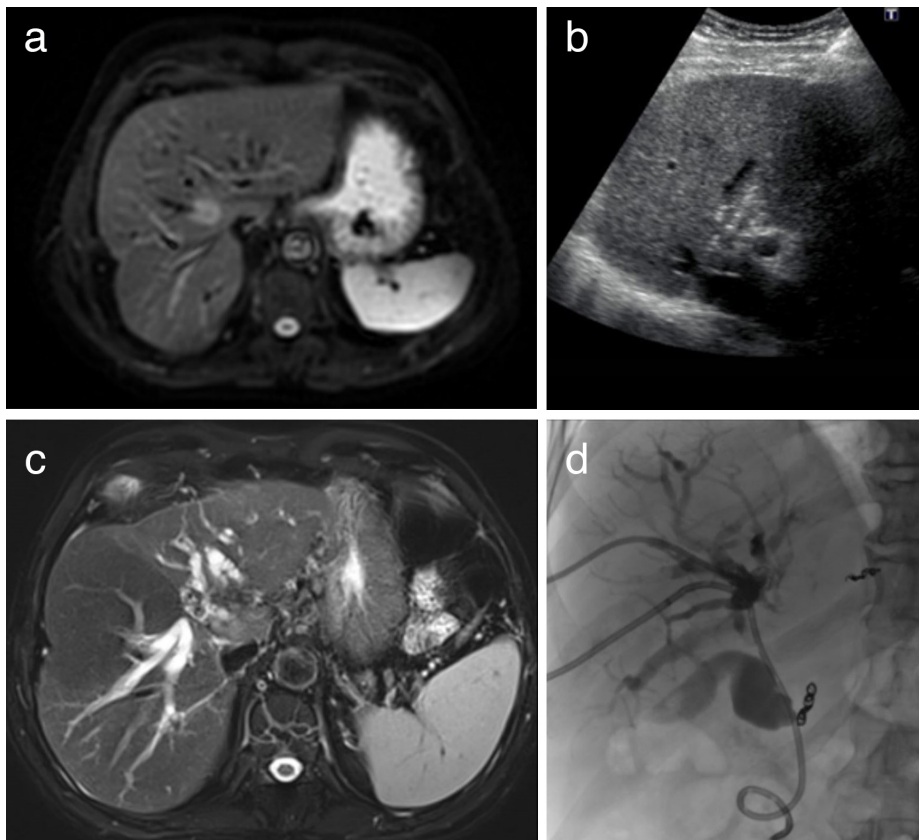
Biliary obstruction after RFA of CRC metastasis. A segment 4b metastasis is seen on the fat-suppressed T2-weighted slice (a). Ultrasound-guided percutaneous radiofrequency ablation is performed (b). Approximately nine months after the procedure, the patient developed biliary dilatation (c) due to the central ablation scar, and percutaneous biliary drainage (d) was performed. RFA, radiofrequency ablation; CRC, colorectal carcinoma.
